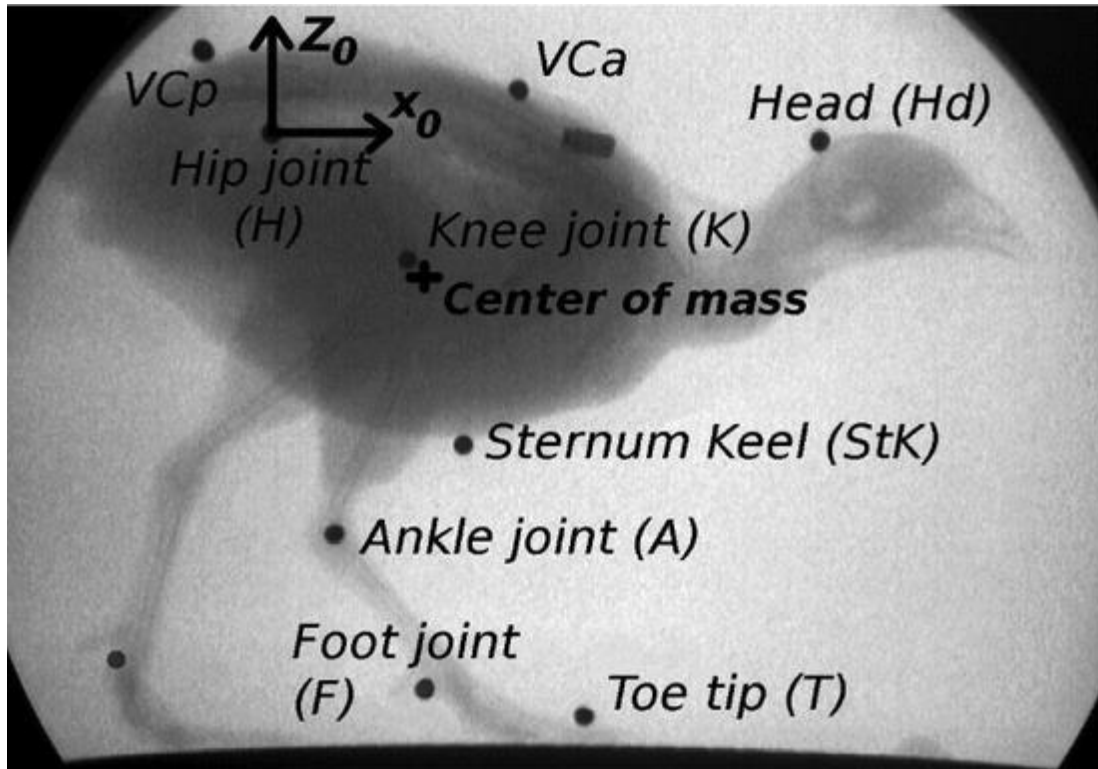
(Side view) X-ray image of quail with lead balls to mark vertebral column anterior point (VCa), vertebral column posterior point (VCp), hip joint (H), knee joint (K), ankle joint (A), foot joint (F), toe tip (T), head point (Hd), and sternum keel point (StK). The center of mass is located approximately between the knees. Lead balls were stuck along one leg only to avoid confusion during the coordinate-extraction process. Coordinate frame is fixed to the hip joint. x_0 is in the direction of motion. z_0 is the vertical axis. (from Hugel et al. 2011.)
